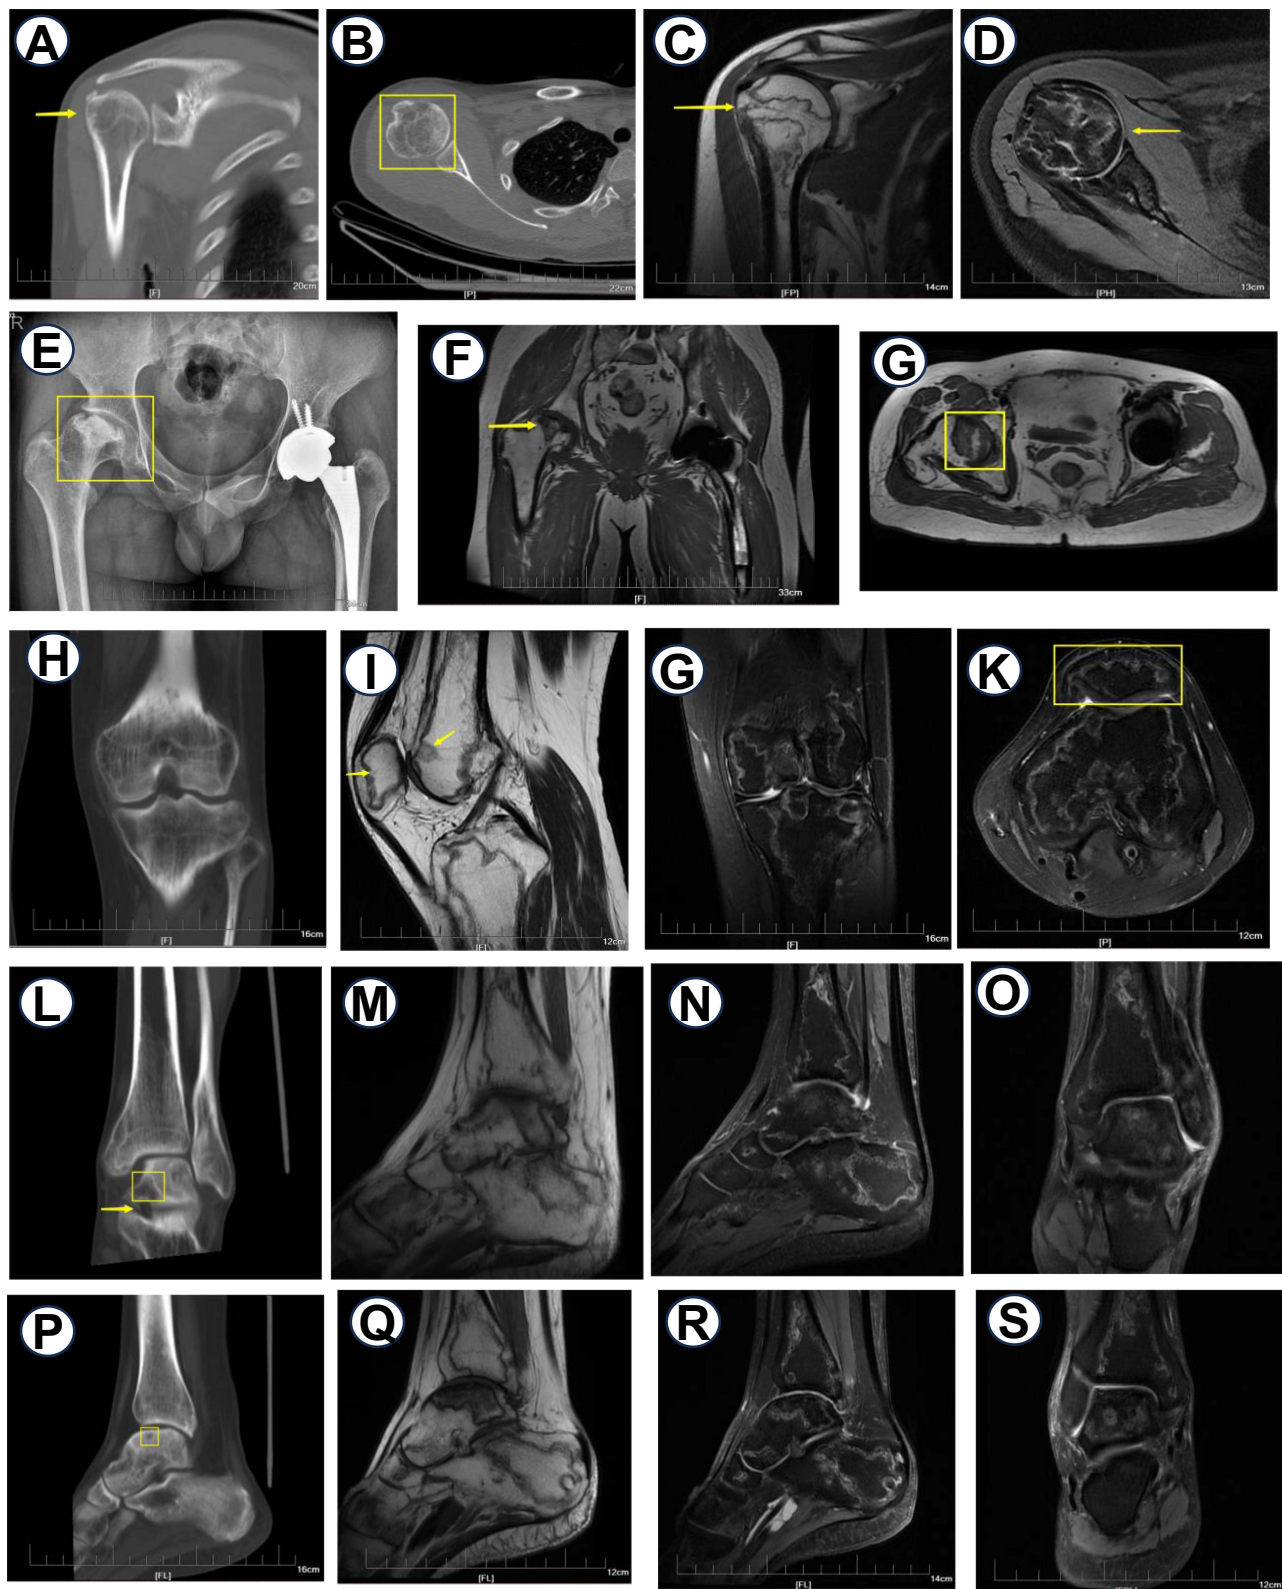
Imaging examination results of the right shoulder joint, bilateral Hip joint, left knee joint, and bilateral ankle joint. The typical lesion area is marked with yellow arrows and boxes. (A and B) CT: speckled dense shadow is seen on the outer edge of the right human tuberosity (C and D) MRI: T1WI shown low signal, and multiple patches and line like changes were seen; T2WI showed high signal, and geographic map like changes were seen; (E) X-ray: the right femoral head collapsed; (F and G) MRI: the right femoral head is collapsed; T1WI shows low signal, and multiple patches and line-like changes can be seen; T2WI and FS-PD show high signal, and map-like changes can be seen; (H) X-ray: hypodense shadow around the lower end of the femur and tibial joint on the left side. (I-K) MRI: bone signal abnormality can be seen in the left distal femur and proximal tibiofibula; (L) X-ray: hypodense shadow under the articular surface of the right talus. (M-O) MRI: bone signal abnormality was seen in the right distal tibia, distal fibula and multiple tarsal bones. (P) X-ray: hypodense shadow under the articular surface of the left talus. (Q-S) MRI: Bone signal abnormalities are seen in the right distal tibia, distal fibula, and multiple tarsals.
